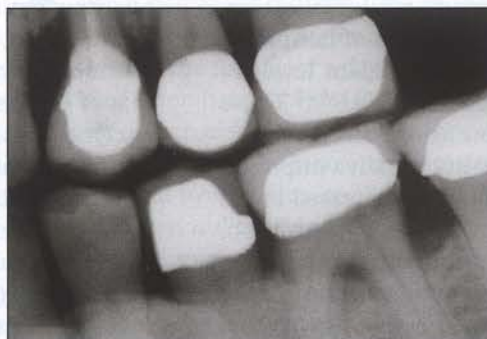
Radiograph showing deep and defective subgingival margins that had a negative effect on periodontal health throughout time.
